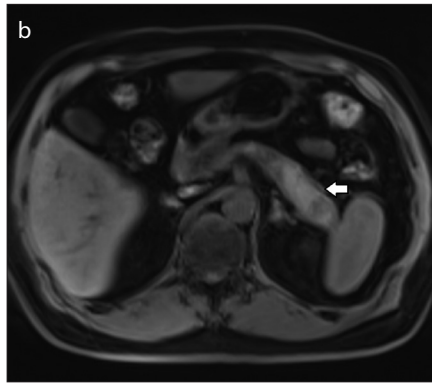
a, b. Axial CT image (a) shows autoimmune pancreatitis (left arrow). The pancreatic tail is bulky with enhancement and loss of fat cleft. A hypodense rim surrounding the pancreatic tail is thought to represent fibrous tissue. Axial T1-weighted image (b) shows bulky pancreatic tail with T1-weighted hyperintensity. Surrounding fibrotic tissue is seen as T1-weighted hypointense rim, better depicted on MRI than on CT.
